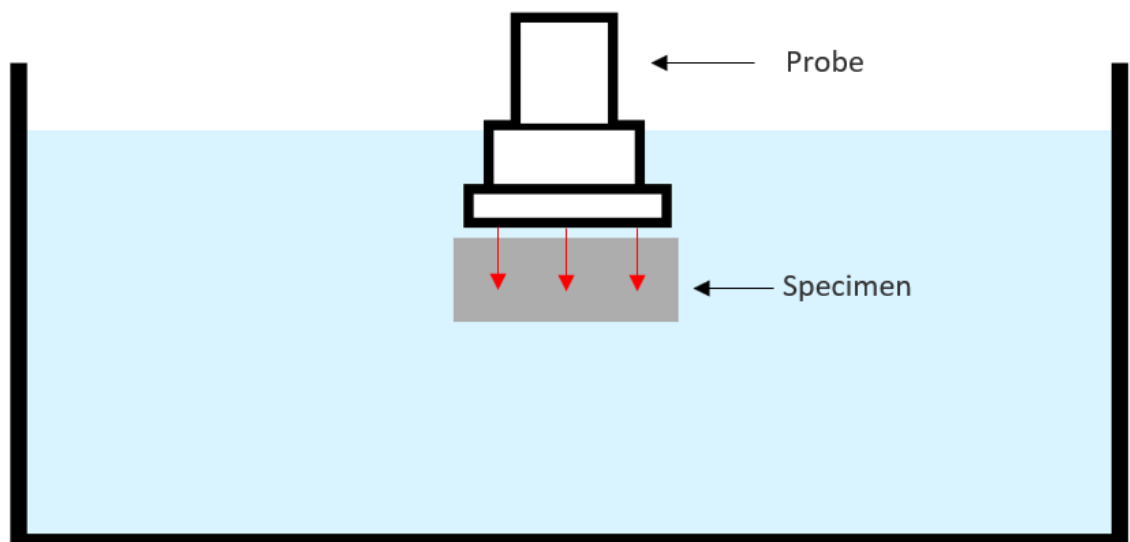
Ultrasound experiment setup
